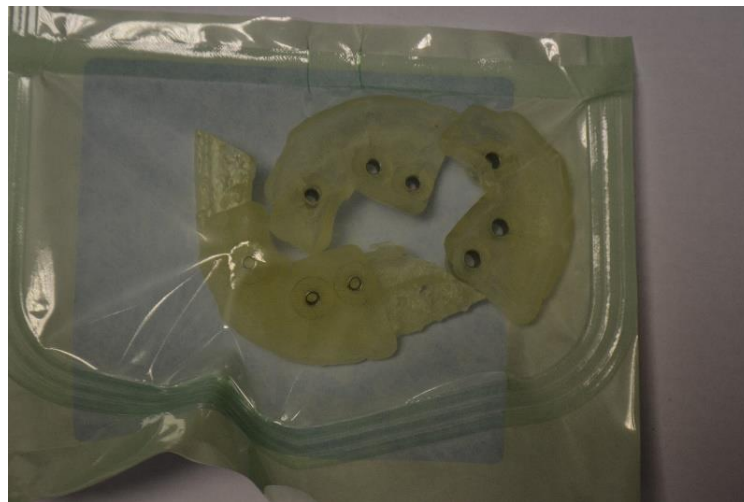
Surgical bone fitted implant guides to be used at time of implant placement that were produced from a dual Scan CBCT from patient.
